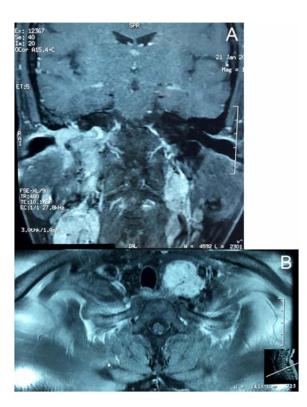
T1W MRI with Gadolinium showed enhancing iso-hyposignal mass at the right jugular fossa (A), right and left carotid bulb, and at the left superior mediastinum (B).
